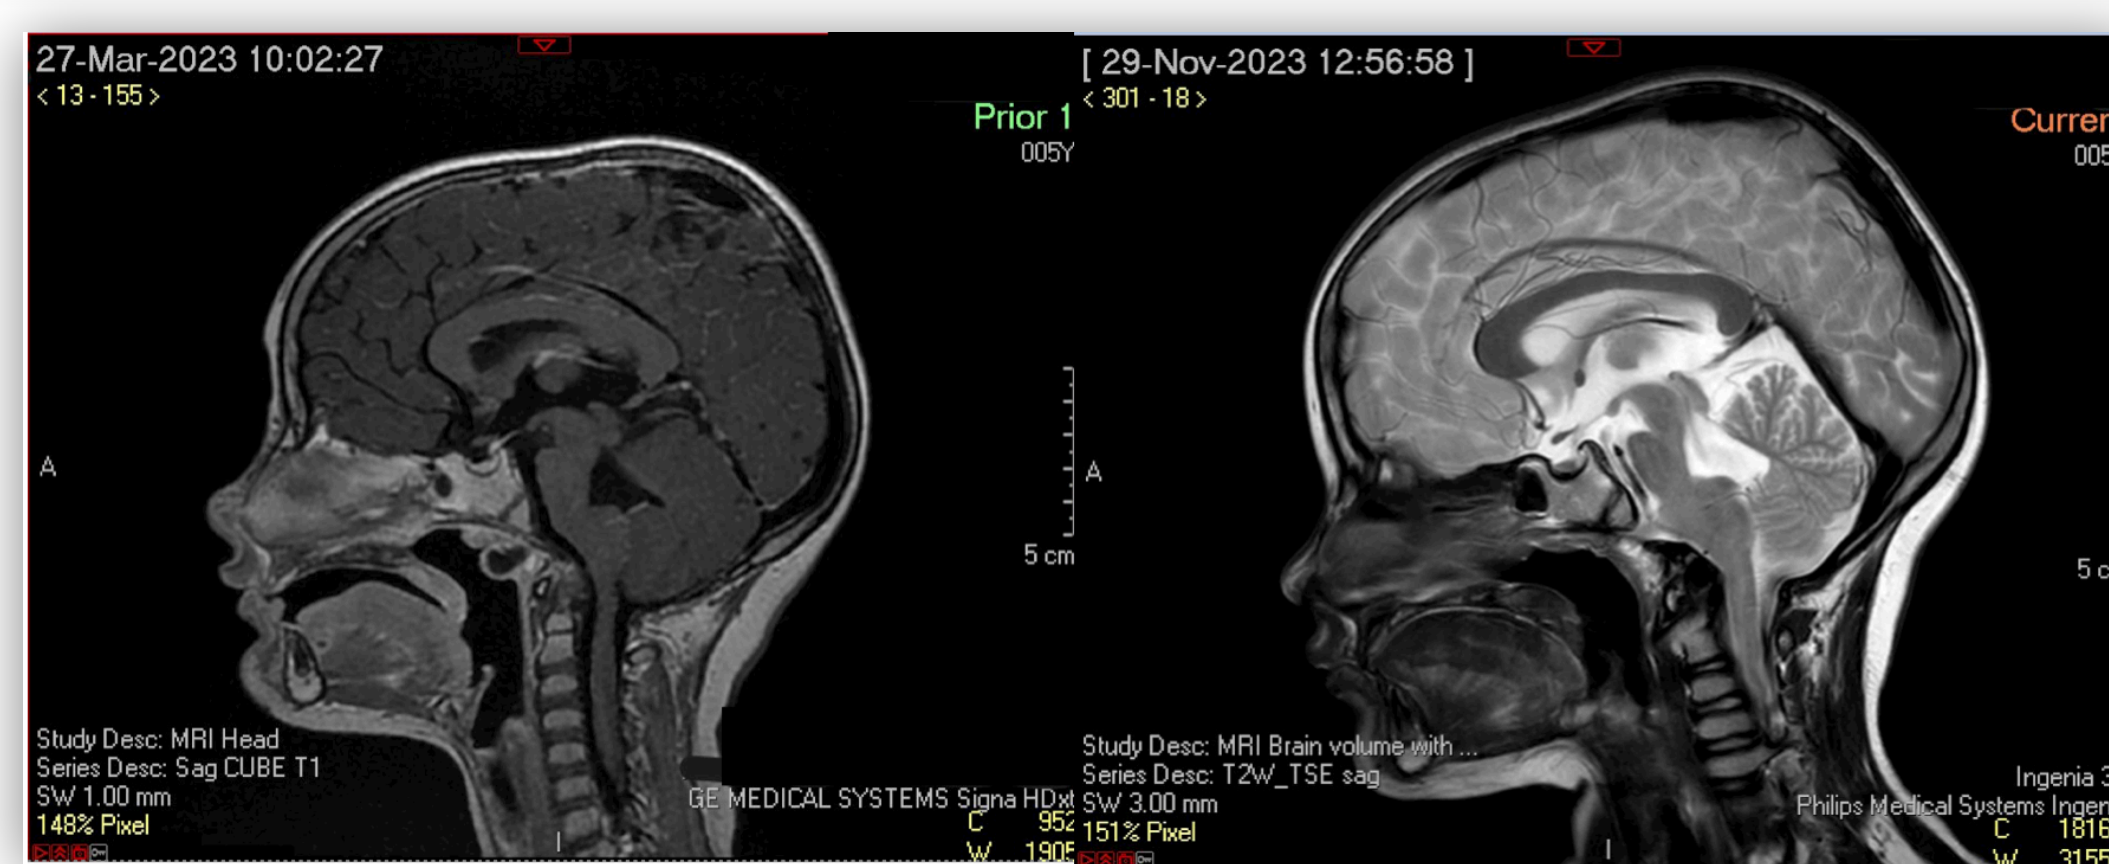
MRI Head scan showing preoperative (left) and postoperative (right) appearances.
